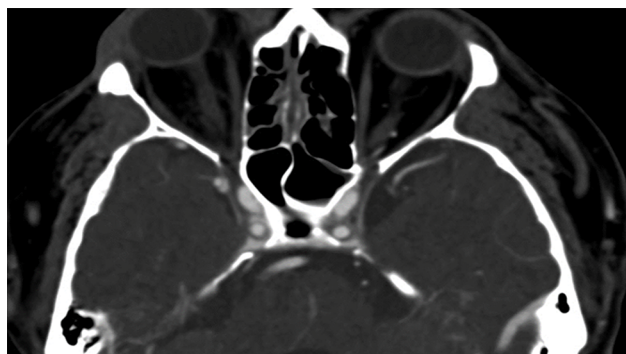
CT with contrast enhancement, axial slice. Thrombosis of the right sinus cavernosus.
